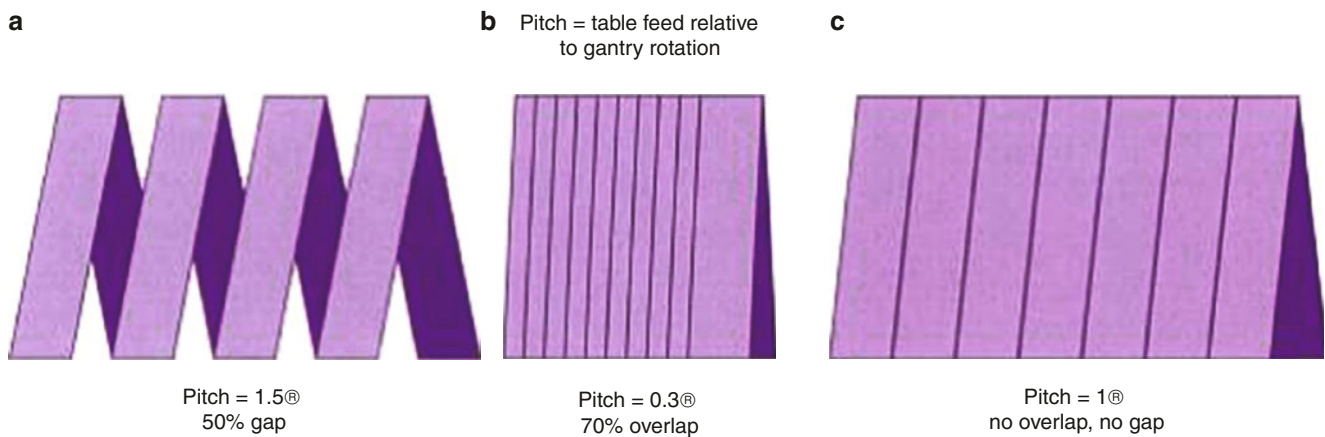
Image acquisition: gantry rotation. The standard mode by which CT images are reconstructed is a “half-scan” reconstruction algorithm. As the gantry rotates around the patient, the scanner bed moves forward, producing a spiral path relative to the patient
